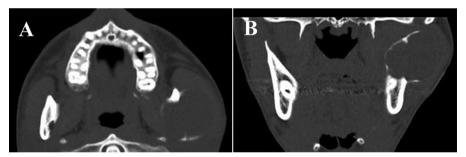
Computed tomography scan. A, Axial view demonstrating a bony cystic lesion in the temporomandibular joint and mandibular fossa of the temporal bone. B, Coronal scan also showing bony cystic lesion with extension inferior to the impacted third molar tooth.
